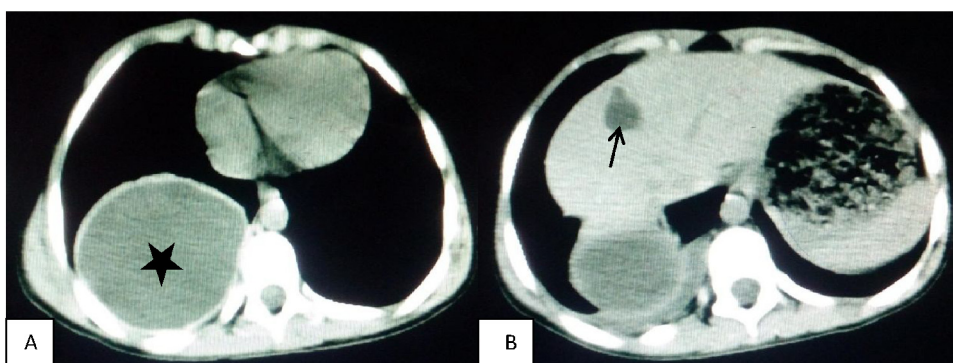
Chest and abdominal CT scan with contrast: A: chest CT shows the 10*8 cm cyst in the right lower lobe of the lung(black star). B:abdominal CT reveals the small 1.5*2 cm cyst in the right lobe of the liver(black arrow).
